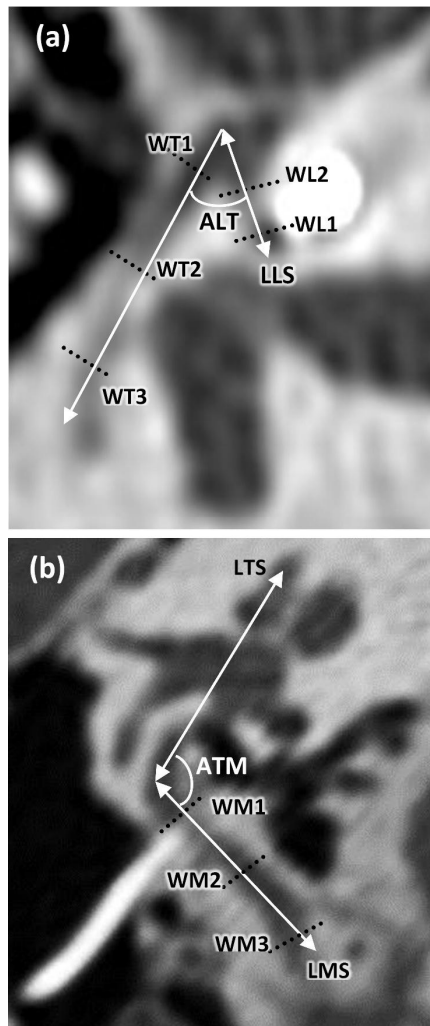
CT-based measurements of the facial nerve landmarks for one FN. (a) Axial view showing the angle between the labyrinthine and tympanic (ALT) segments, the widths (diameters) of the labyrinthine and tympanic segments (WL1, WL2, WT1 – WT3) as well as the length of the labyrinthine segment (LLS). (b) Oblique coronal view showing in the angle between the tympanic- and mastoid segments (ATM), the widths of the mastoid segment (WM1 – WM3) as well as the lengths of the tympanic- and mastoid segments (LTS, LMS).
